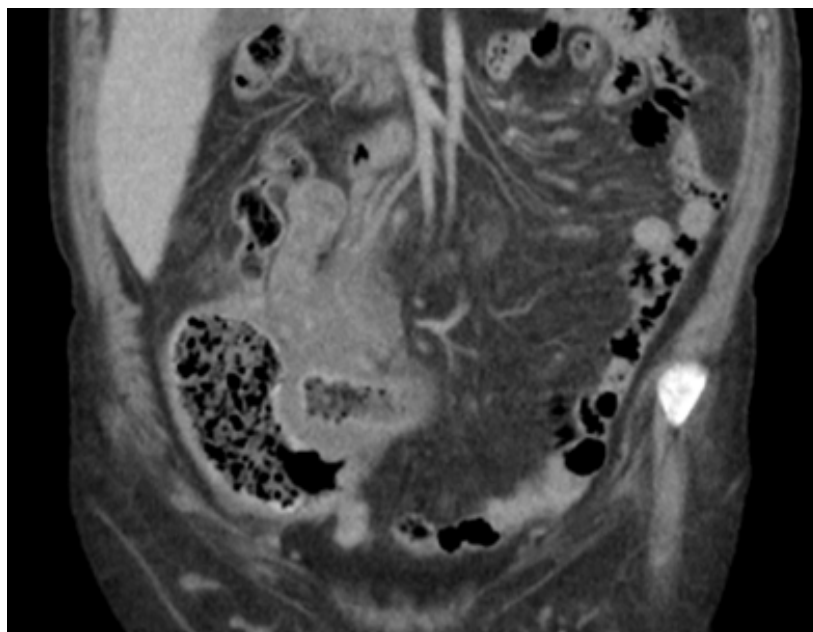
Long segment tumor involvement of the ileocecal valve that does not narrow the lumen in coronal abdominal CT sections.
